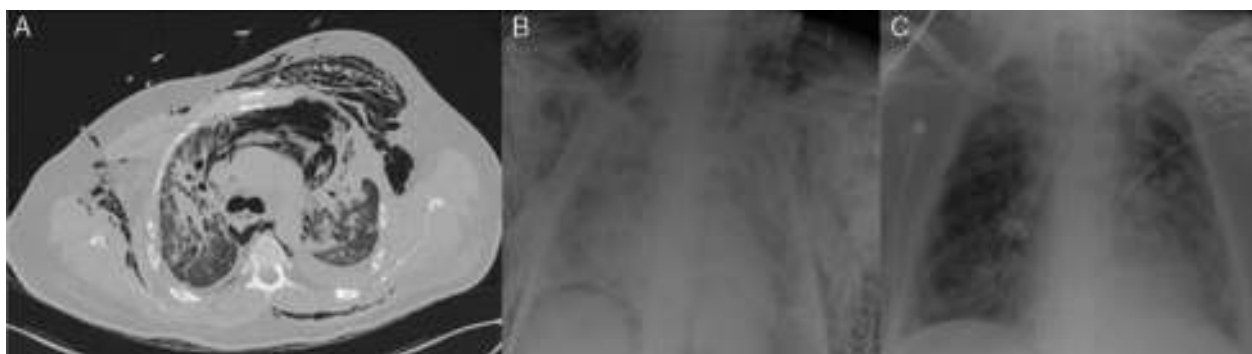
(A) CT image, showing significant subcutaneous emphysema and pneumomediastinum. (B) Portable chest X-ray showing subcutaneous emphysema, bilateral alveolar-interstitial infiltrate and selective right intubation. (C) Portable chest X-ray, several days after placement of tracheal stent.
